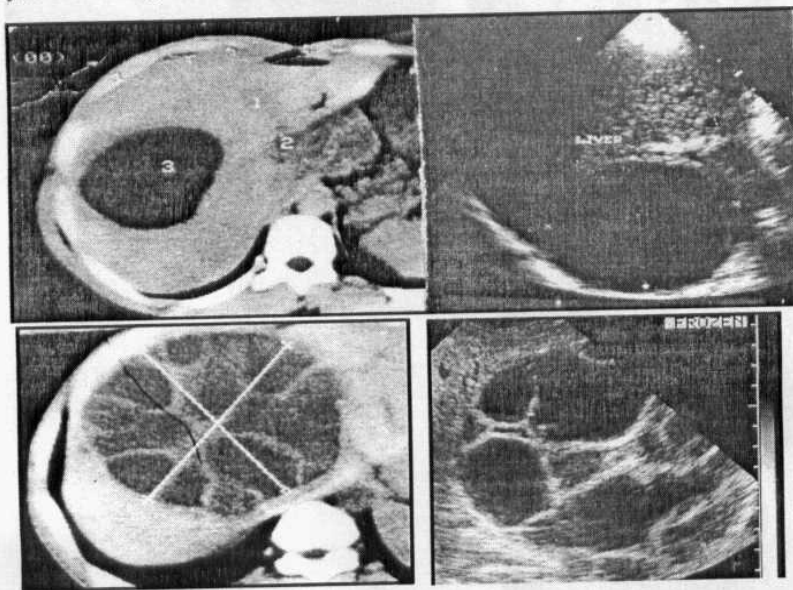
US and CT showed unilocular hydatid cyst of the liver (a), and multilocular in (b).
